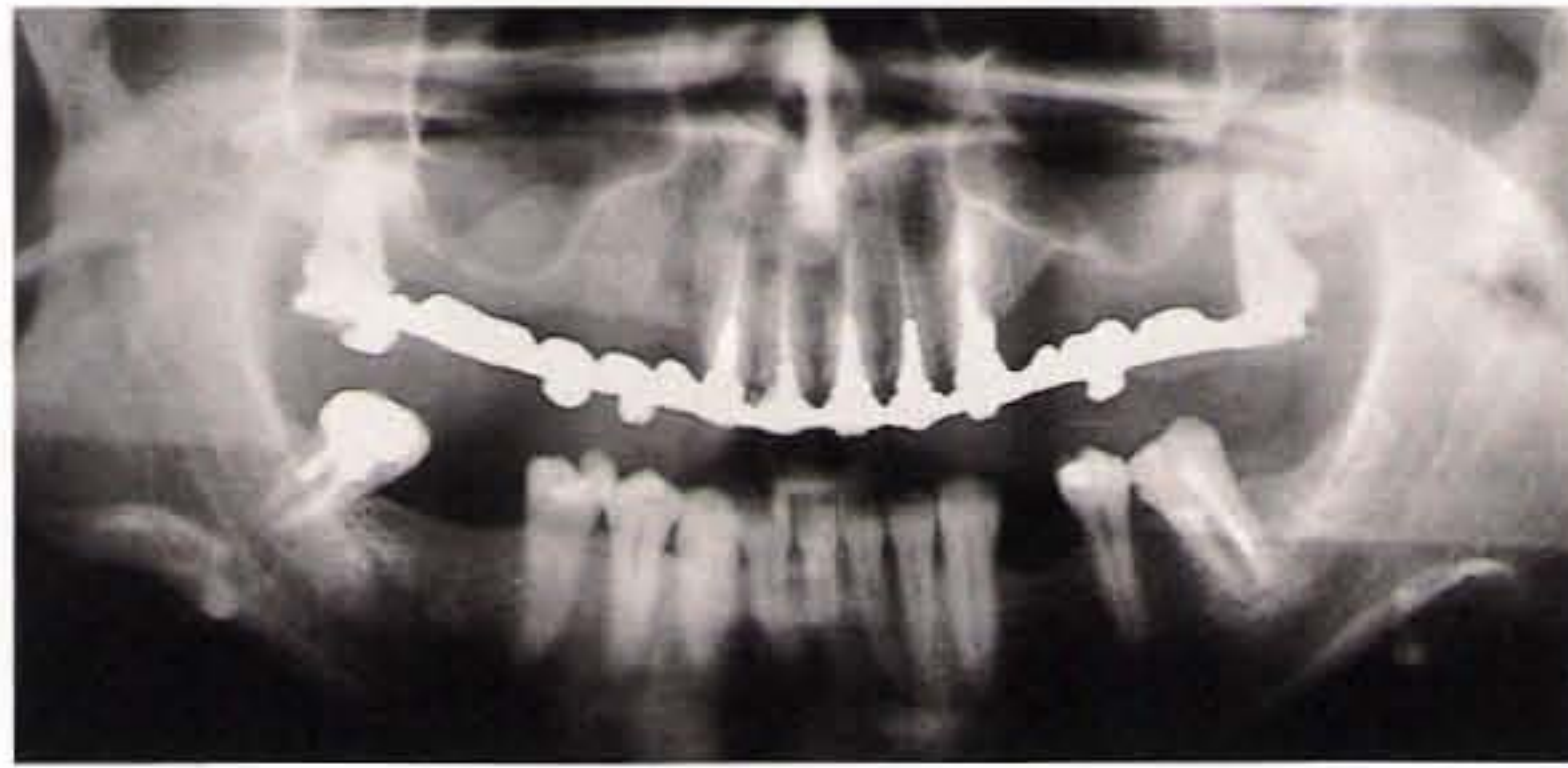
Initial panoramic radiograph. The patient has a provisional fixed prosthesis of reinforced resin, ideal for the waiting period until the implant has healed.
